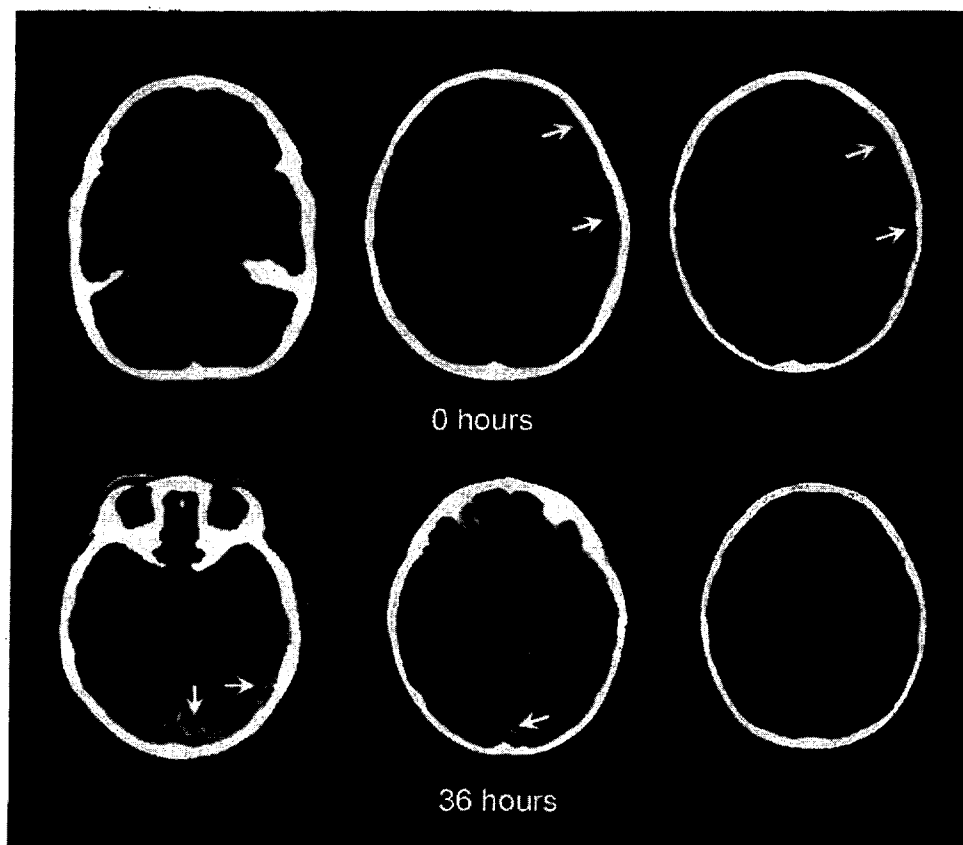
Images obtained from a 9-month-old female infant who had accidental trauma from left-side frontal impact. Computed tomographic images at presentation (top row) show left-side frontotemporal-convexity high-density subdural hemorrhage (arrows). Computed tomographic images obtained after 36 hours in the hospital (bottom row) show redistribution of the high-density hemorrhage to the peritentorial region and posterior interhemispheric fissure (arrows).
